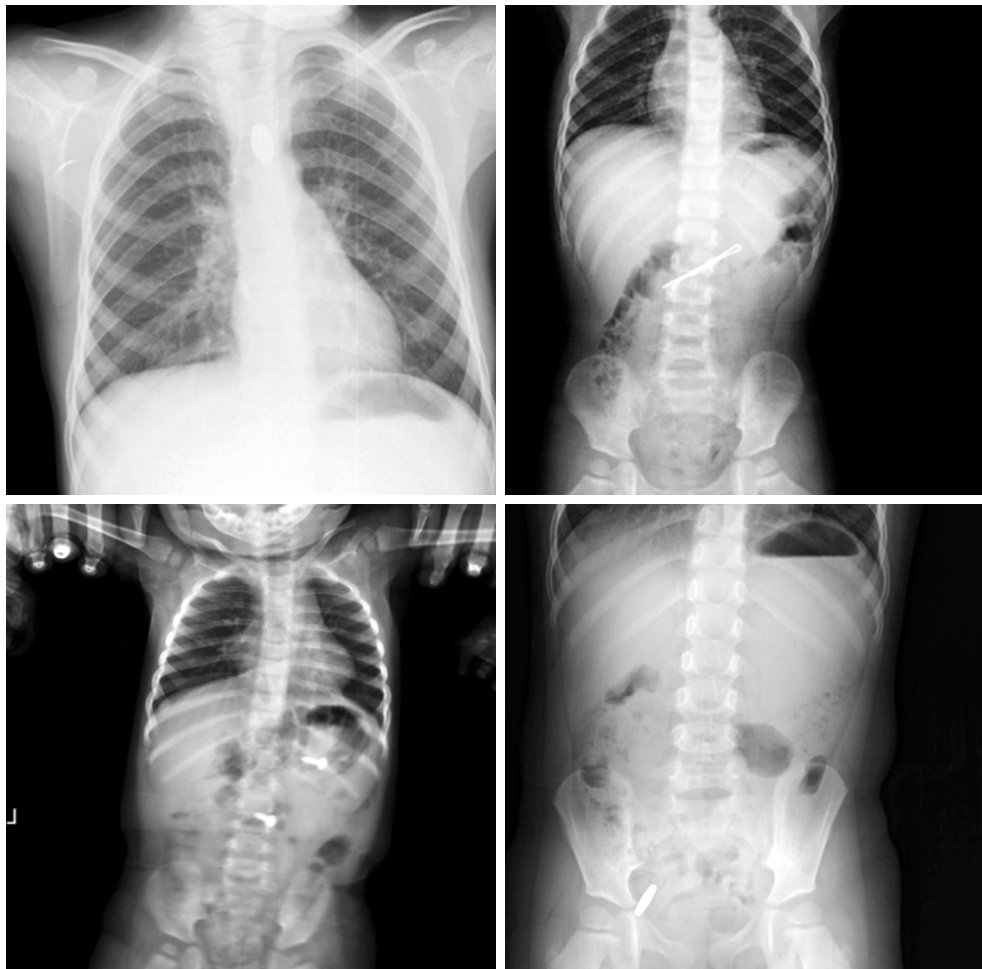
X-ray view of the placement of different foreign bodies in different localizations.
